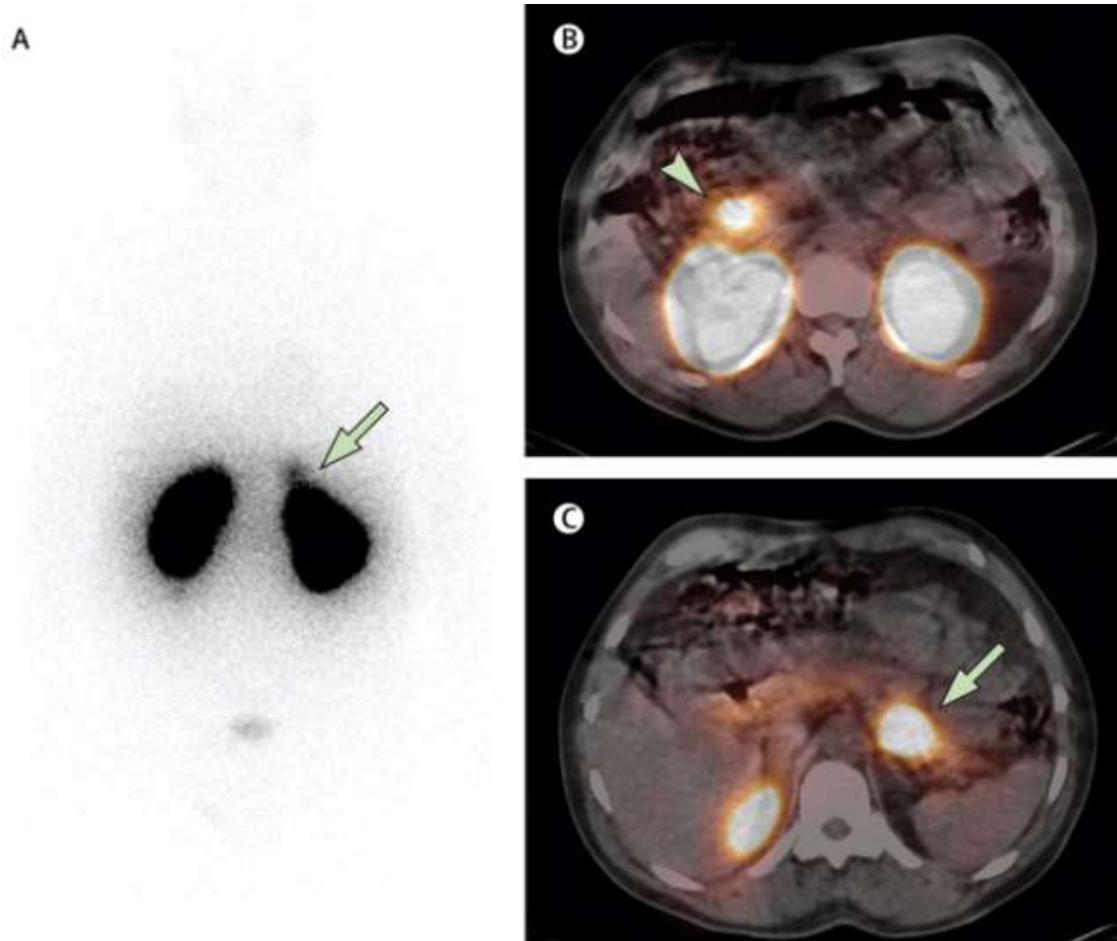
Whole-body planar images (A) and SPECT-CT images (B and C) at 4 hours post-injection of 108 MBq of ^{111}In -DTPA-exendin-4 (Christ et al., 2013).
